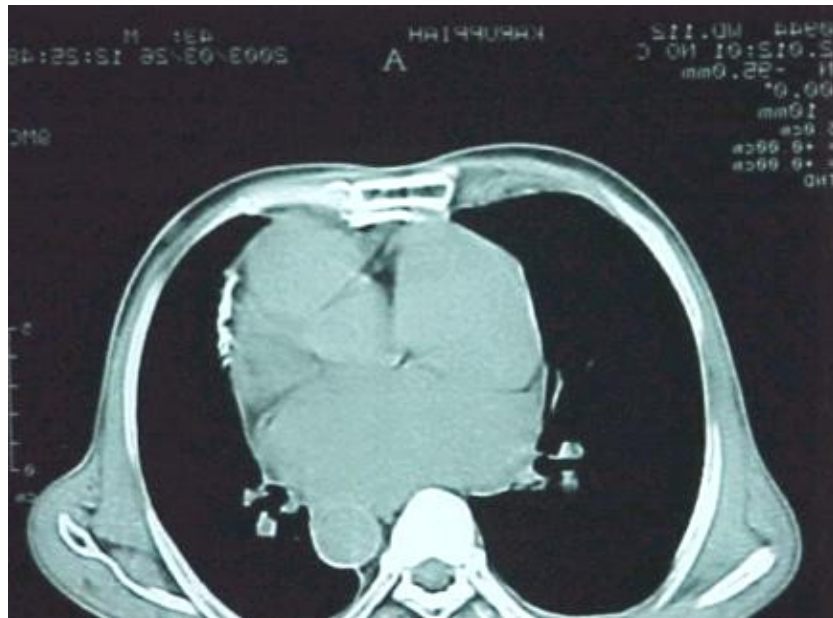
10 CT scan showing pericardial calcification in a patient with CCP.
